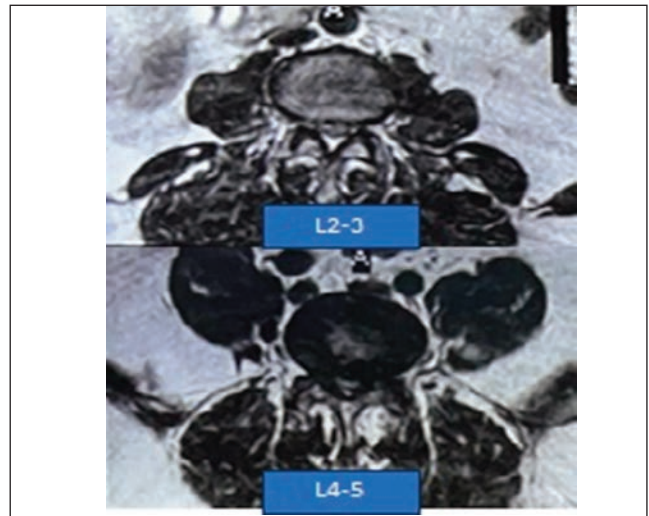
Pre-op MRI of patient.
